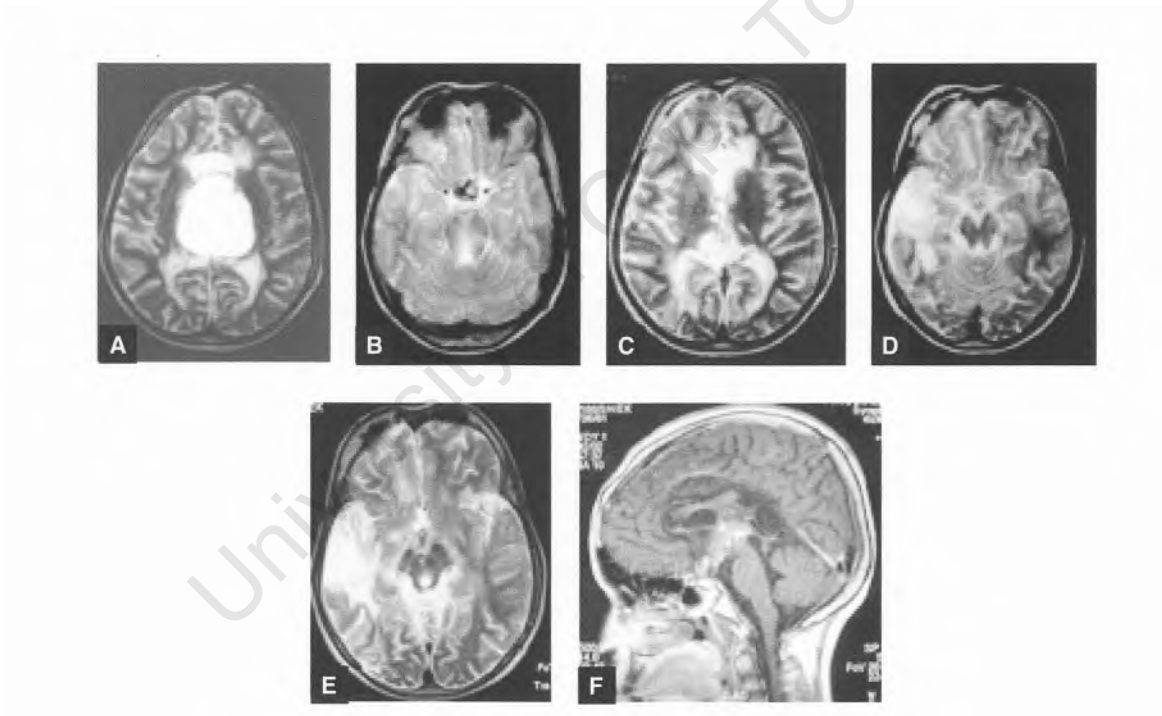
Axial T2 MRI at time of tumour recurrence (a) and follow-up image at 6 months demonstrating a CR (b and c); a further follow-up scan at one year showed new hyperintense signal changes in right temporal lobe (d) which had initially been normal in appearance; this was more marked 4 years later (e) although long-term control of the tumour is apparent on the sagittal image with contrast (f).
